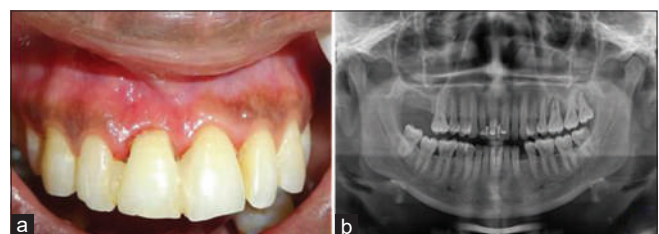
(a) Postoperative clinical view after 1 year. (b) Postoperative radiographic view after 1 year
